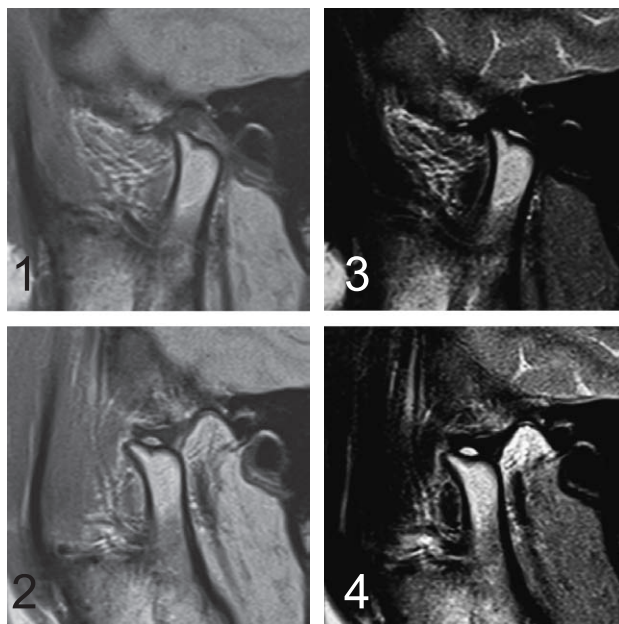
Sagittal MRI (32Y1M). MRI follow-up after 8 years showed a normal joint function and decreased cystic mass.
